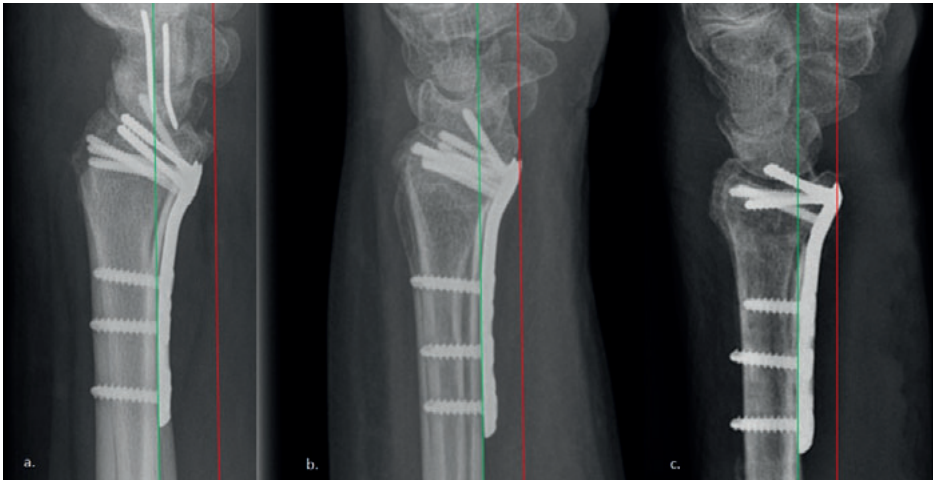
Lateral radiographs of a distal radial fracture treated with a DVR plate demonstrating (a.) Soong Grade 0 prominence (plate dorsal to critical line), (b.) Soong Grade 1 (plate volar to critical line, proximal to volar rim) prominence and (c.) Soong Grade 2 prominence (volar to critical line, at volar rim). Cohort 1 87 plates (43,5%) were Grade 0, 95 plates (47,5%) were Grade 1 and 18 plates (9,0%) were Grade 2.
